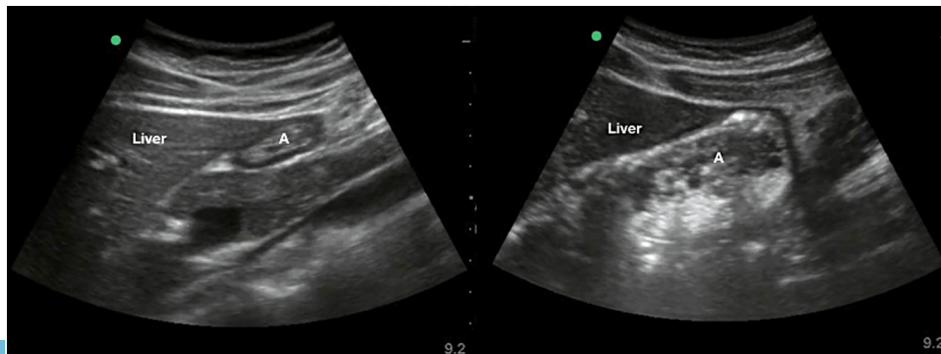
Ultrasound scans of an empty and content-filled gastric antrum.
